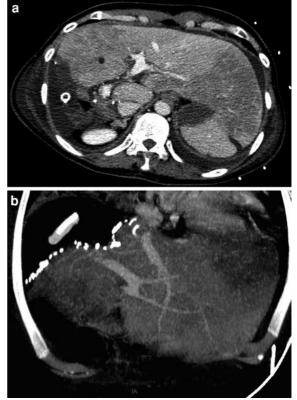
Contrast-enhanced CT after right hepatectomy: Postoperative Budd-Chiari syndrome. a axial view at the portal venous-phase; note the left liver congestion because of compromise of hepatic venous outflow. b coronal MIP view at the portal venous-phase; note the stenosis of the distal part of the left hepatic vein
